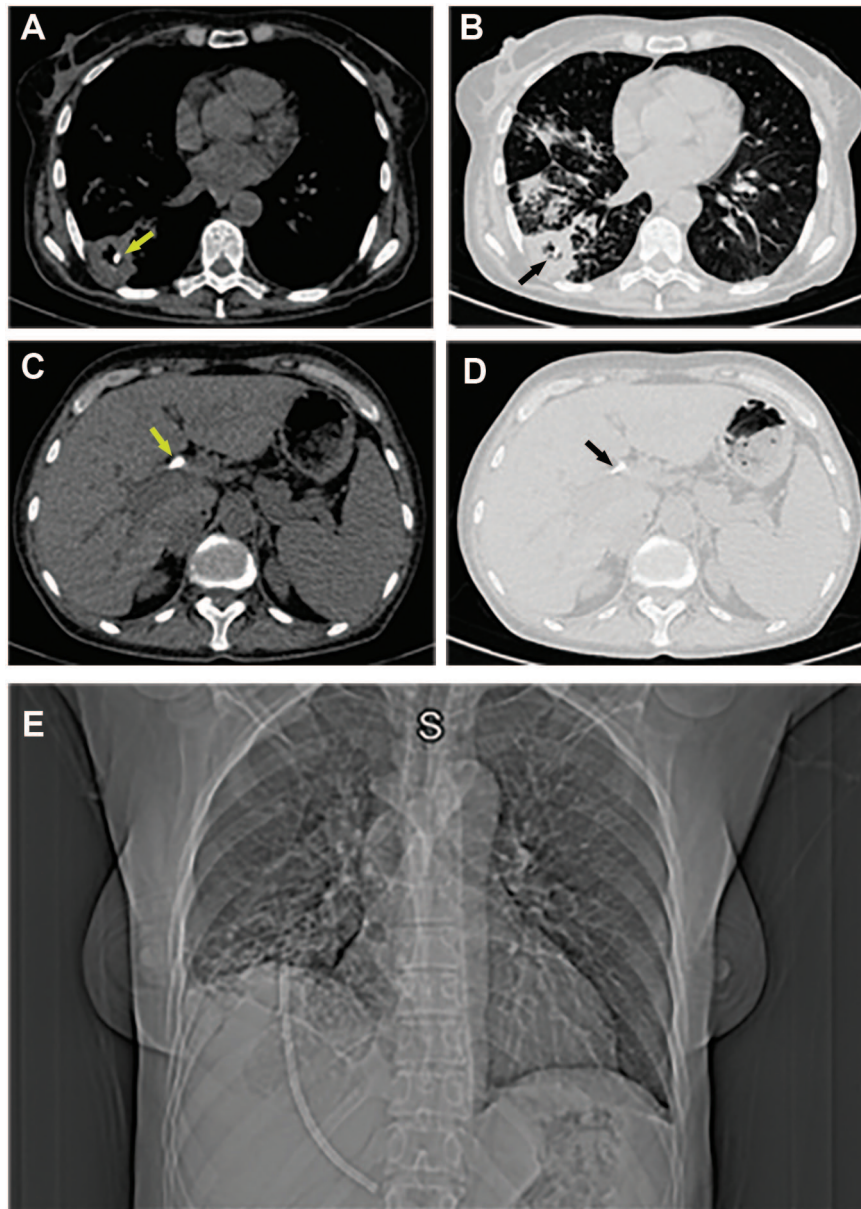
Chest and abdomen CT scan: A and C—Routine 1.5 B31s; B and D—Routine 1.5 B70s; E—Topogram 0.6 T20f. (A and B) The proximal end of the stent is located in the posterior part of the lower lobe of the right lung (indicated by an arrow), surrounded by an infiltration area. (C and D) The distal end of the endobiliary stent (indicated by an arrow) is displaced into the common hepatic duct.
